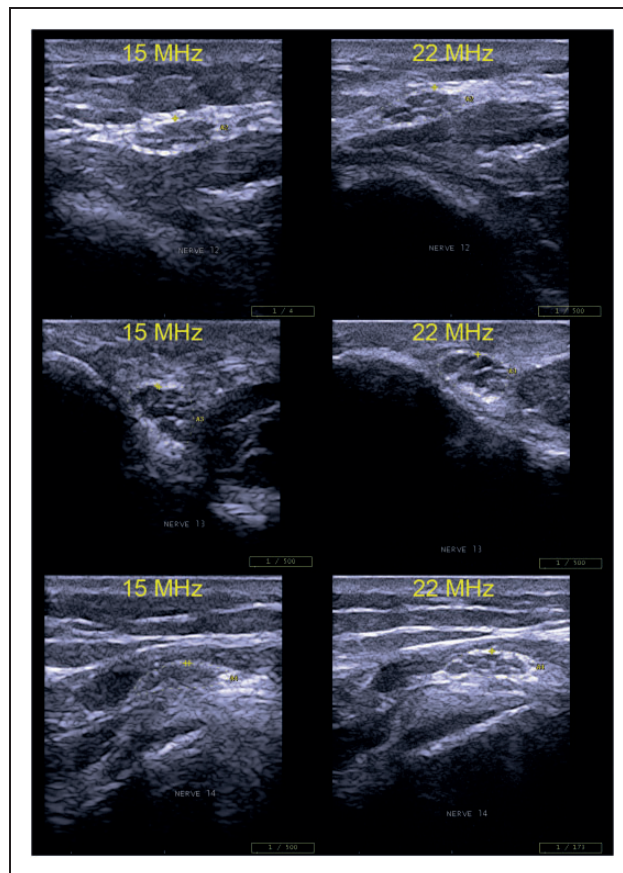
Ultrasonographic pictures of the intraneural architecture depicted with 15 MHz (left) and 22 MHz transducer (right) (Esaote MyLabOne®); top: proximal to the medial epicondyle; middle: medial epicondyle; bottom: distal to the medial epicondyle.
